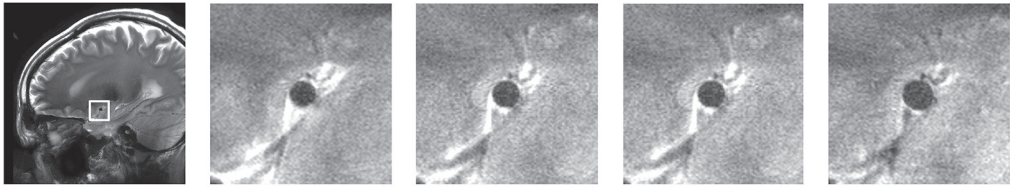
Representative example of high resolution MRI scans planned perpendicular to the MCA. From left to right: the white square depicts the location of the zoomed images; zoomed image at hypocapnia (-1 kPa), baseline normocapnia (0 kPa), and hypercapnia (+1 and +2 kPa end-tidal CO₂) respectively.
